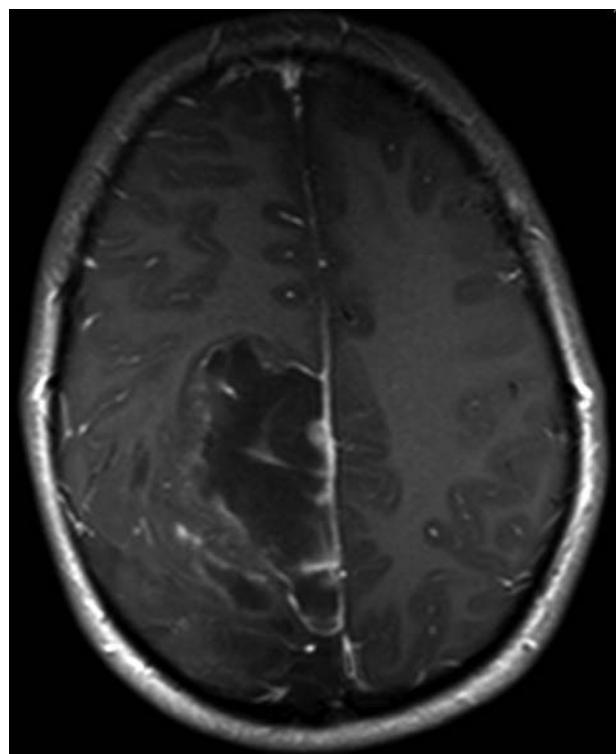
Axial T1-weighted magnetic resonance imaging showing a hypointense right parietal lesion with areas of contrast enhancement.
